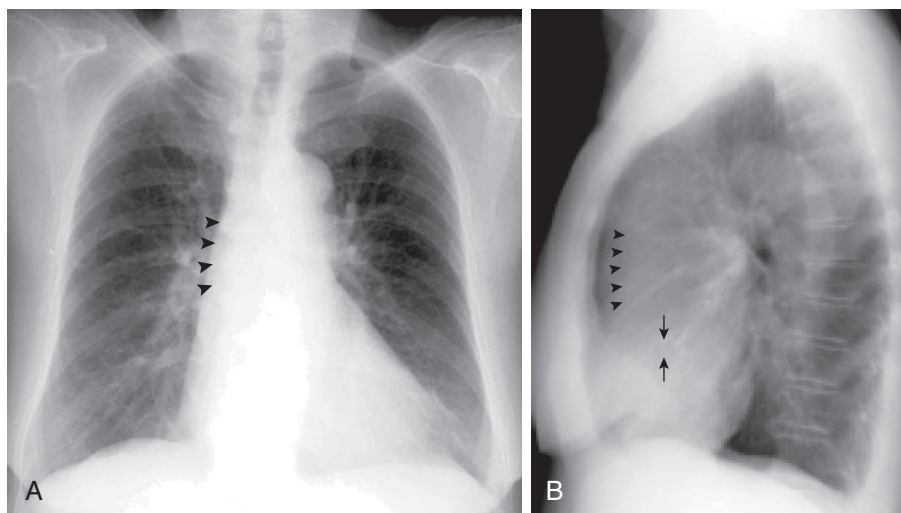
Chest radiographs of a 65-year-old woman with severe aortic stenosis. A, Frontal view showing a prominent aortic root to the right of midline (arrowheads). Note the absence of cardiomegaly and the presence of a normal pulmonary vascular pattern. B, Lateral view demonstrating calcification of the aortic valve leaflets (arrows). There is a prominent, mildly dilated aortic root (arrowheads).
